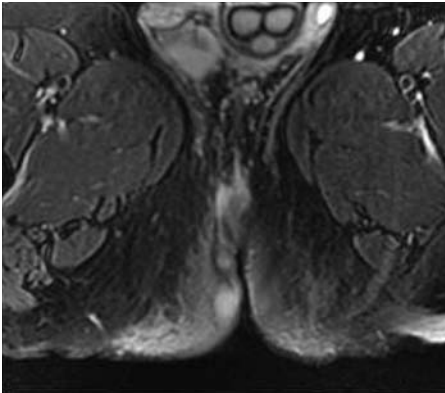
Axial T2-weighted image with fat saturation. Complex fistula with abscesses in the ischioanal fossa
